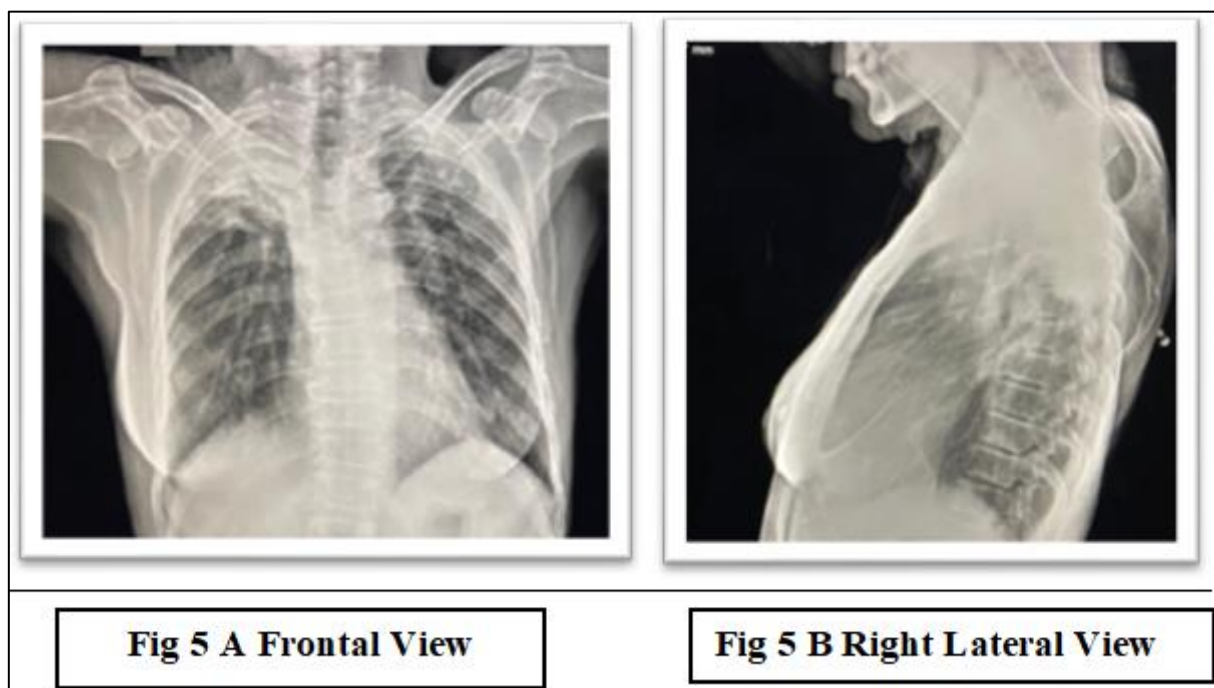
Chest Xray Revealed Mass Lesion in Right Upper Lobe with Spiculated Inferior Margins.
